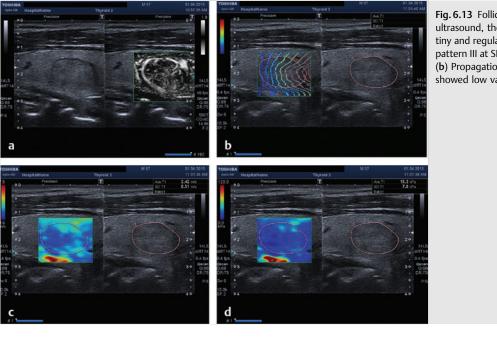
Follicular hyperplasia. (a) At baseline ultrasound, the lesion appears isoechoic with a tiny and regular hypoechoic halo (right side) with pattern III at SMI (Superb Microvascular Imaging). (b) Propagation wave modulus. (c, d) The lesion showed low values at SWE.
